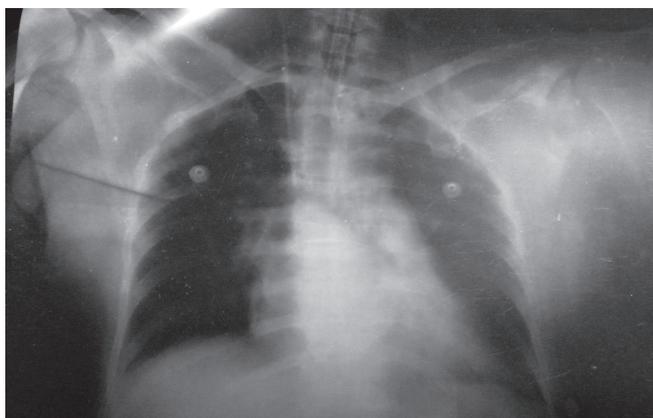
Chest X-ray shows cardiomegaly
